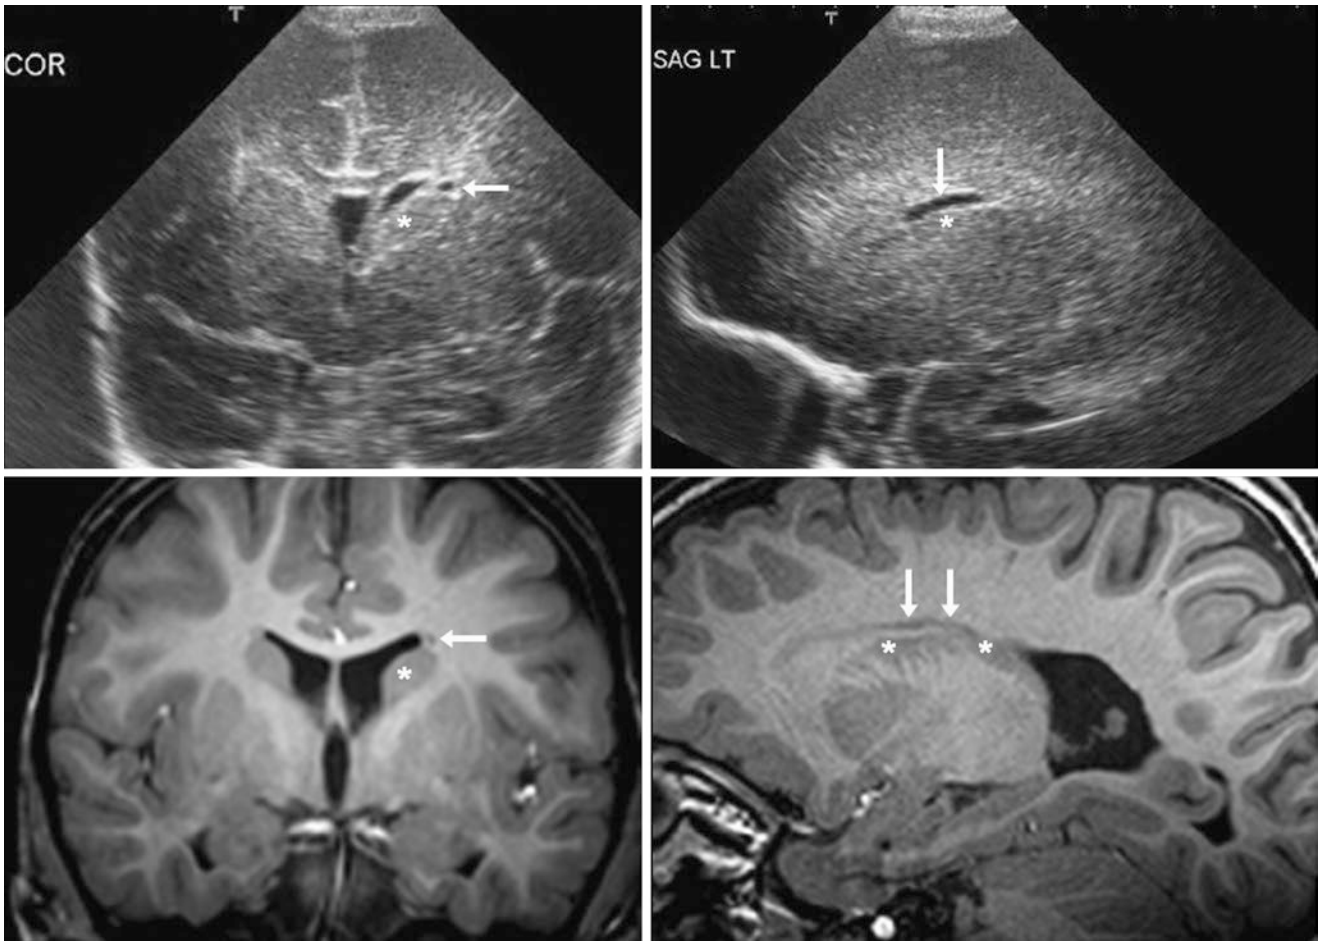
In a 29-week-old premature infant, an US a few days after birth in coronal (*top left*) and sagittal (*top right*) planes demonstrates a left-sided connatal cyst, without white matter hemorrhage, atrophy, or hydrocephalus. A 3 T MRI performed at 2 years of age shows a PEP
